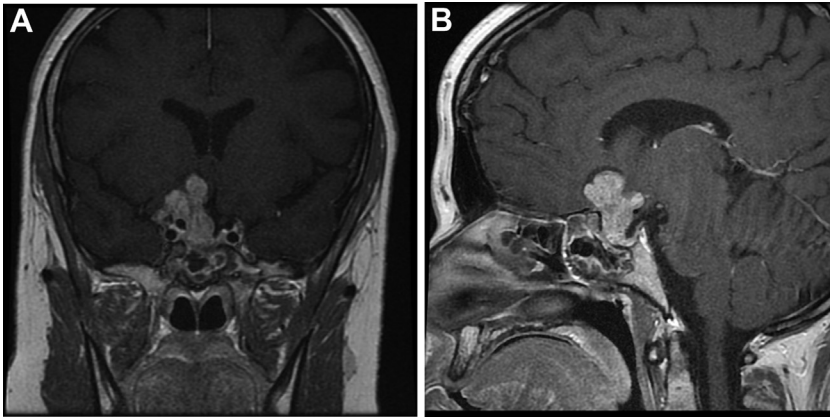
Preoperative magnetic resonance imaging with (A) coronal and (B) sagittal sequences demonstrating the large recurrence of a null-cell pituitary adenoma with suprasellar extension, encasement of the right internal carotid artery and cavernous sinus, and displacement of the anterior cerebral artery on the left side.
